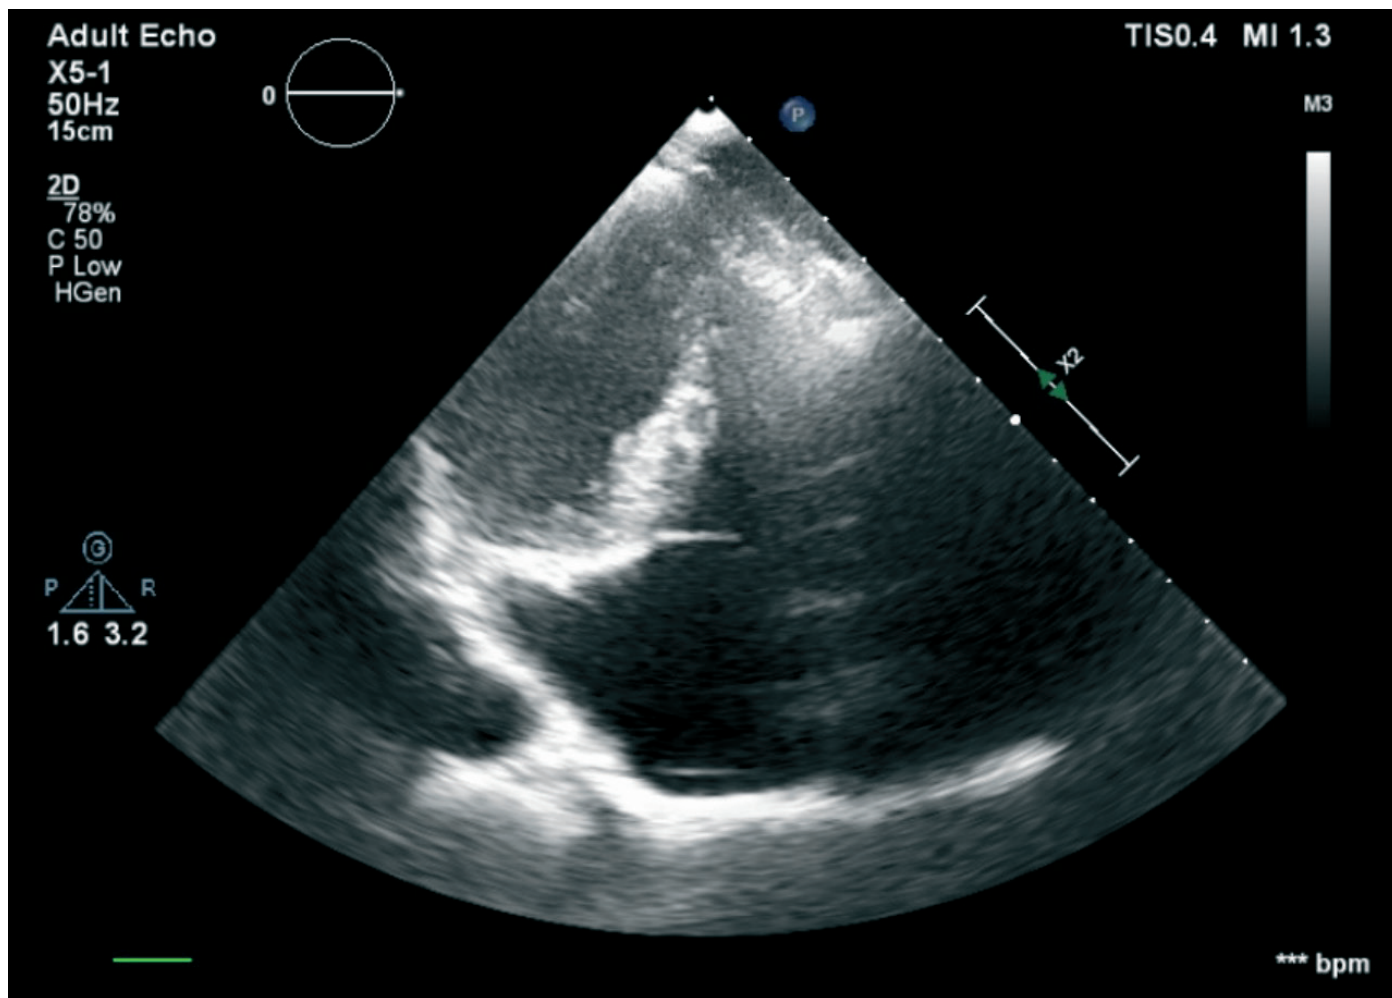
Echocardiographic image
